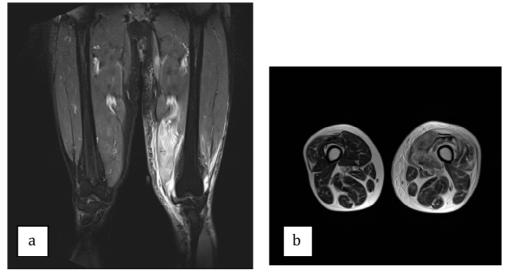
A coronal and axial view of T2 weighted magnetic resonance imaging – high signal intensity in vastus medialis of the left thigh suggestive of muscle inflammation.
